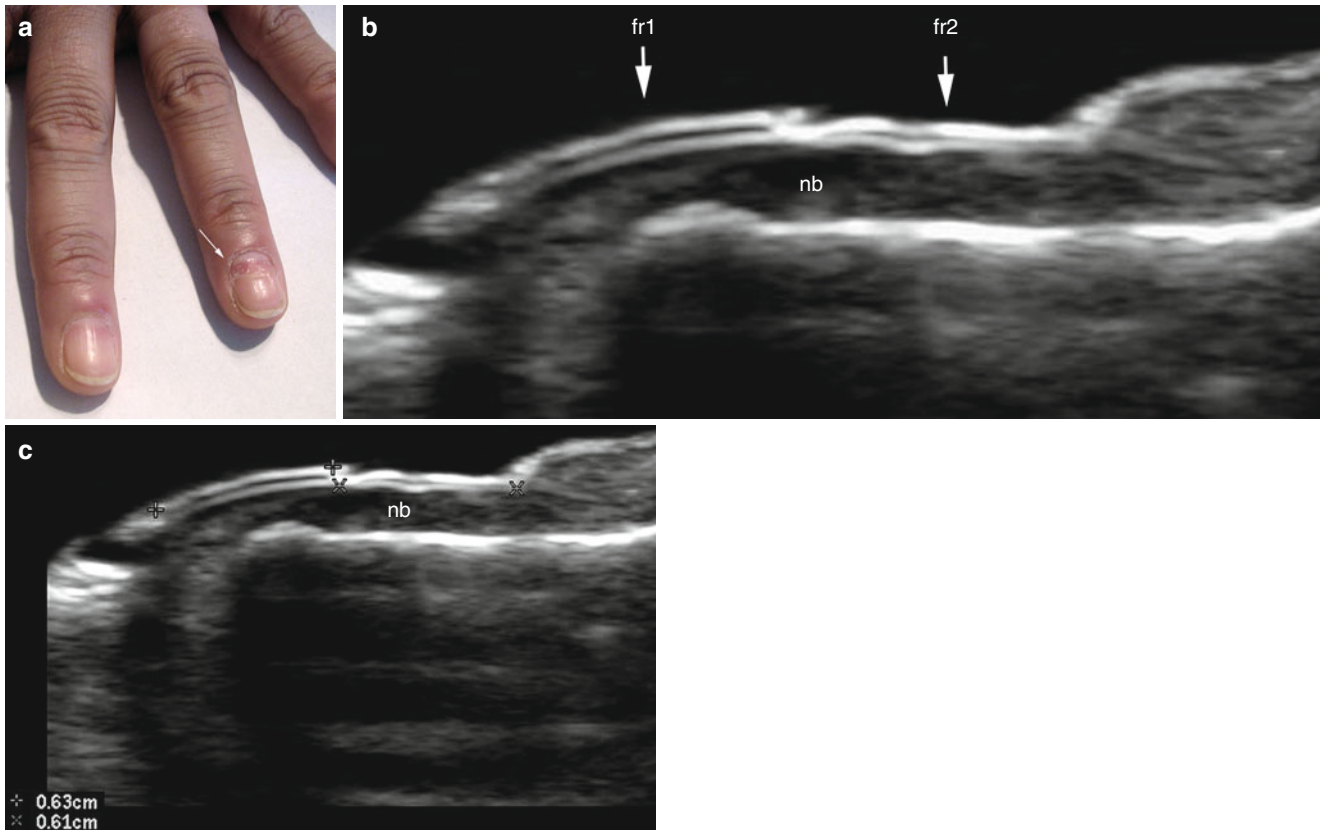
(a–c) Onychomadesis. (a) Clinical image shows nail shedding (arrow) in the nail of the left index finger. (b, c) Grey scale ultrasound images (longitudinal views; b with arrows; c with markers) show
